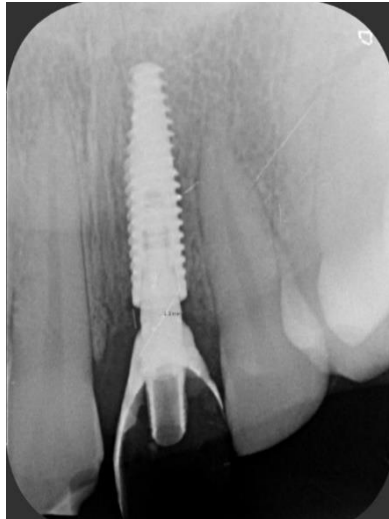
Radiographic image of provisional restoration after relining to shape soft tissue
